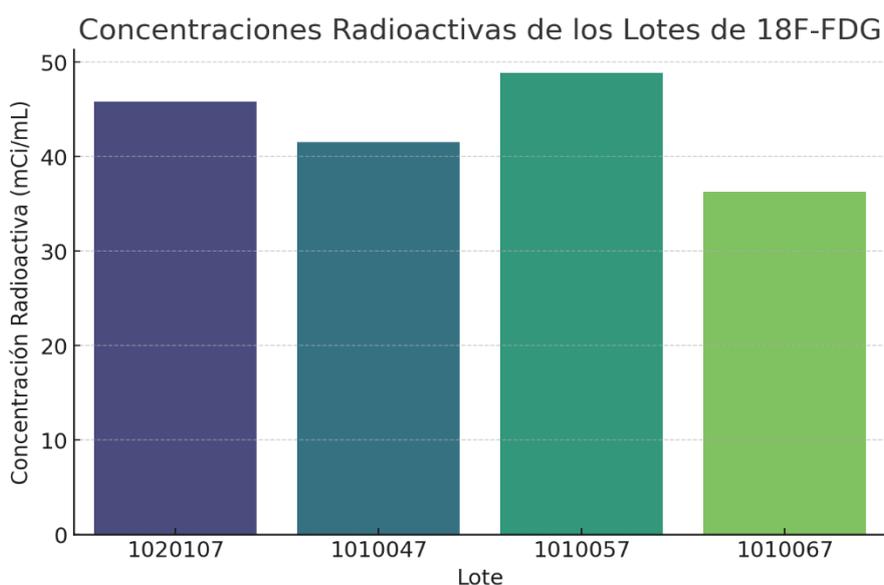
Radioactive Concentration of ^{18}F -FDG Batches
